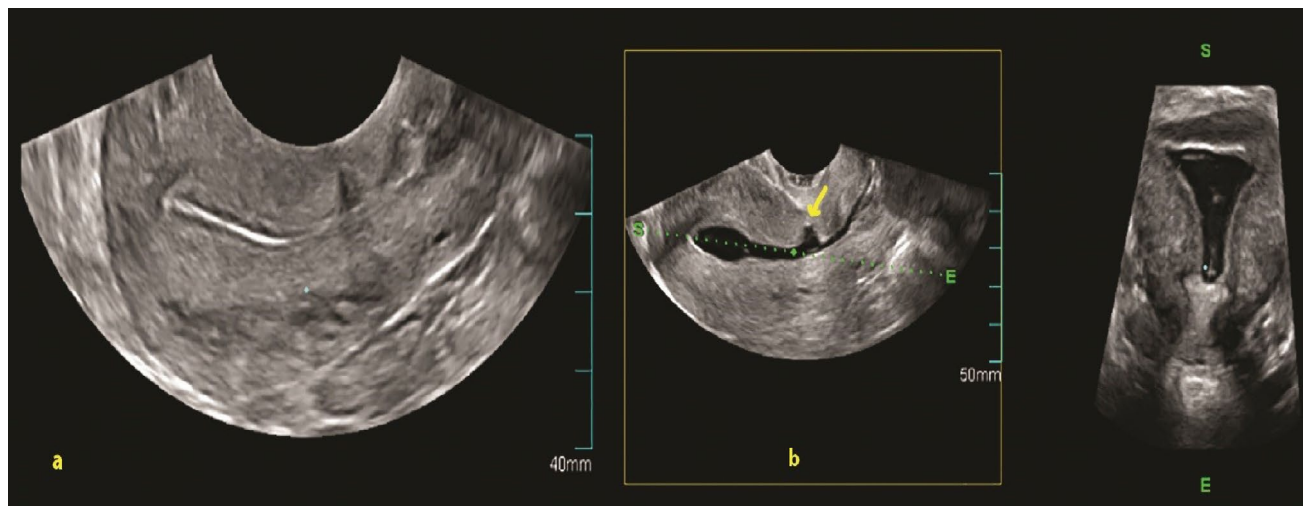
Comparison of 3D transvaginal ultrasound (3D-TVS) and 3D saline infusion sonohysterography (3D-SIS) for imaging the uterine cesarean scar defect (CSD). (a) 3D-TVS image where the CSD is not clearly identifiable. (b) 3D-SIS image of the same patient following saline infusion. The distension of the uterine cavity provides contrast, allowing the CSD (arrow) to become clearly delineated and measurable.
